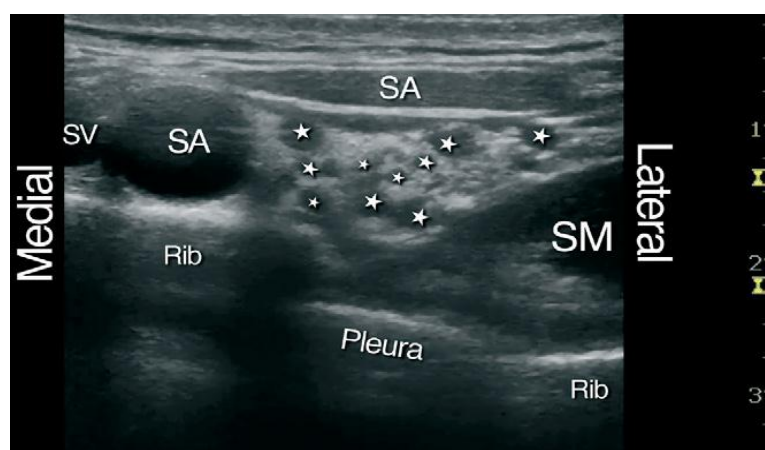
Oblique coronal ultrasound scan of the supraclavicular region. Ultrasound imaging allows for both direct localization of target structures and avoidance of complications. SV and SA, subclavian vein and artery; SA and SM, scalenus anterior and medius muscles. Brachial plexus divisions are indicated by stars.
